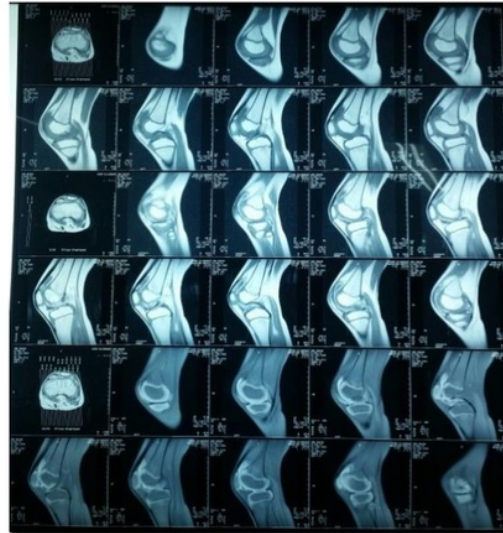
MRI Knee joint showing rim like enhancement of filled bursa
